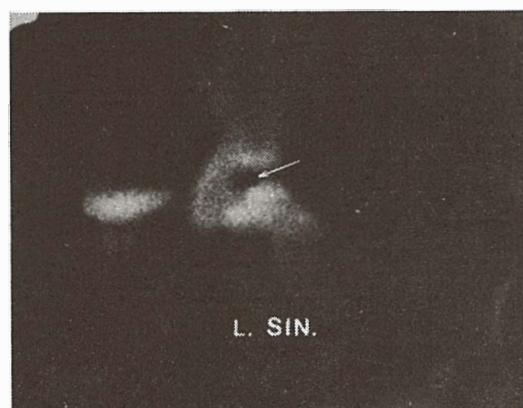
Pinhole scintigraphy of the left femoral head, photon deficient area (arrow)
